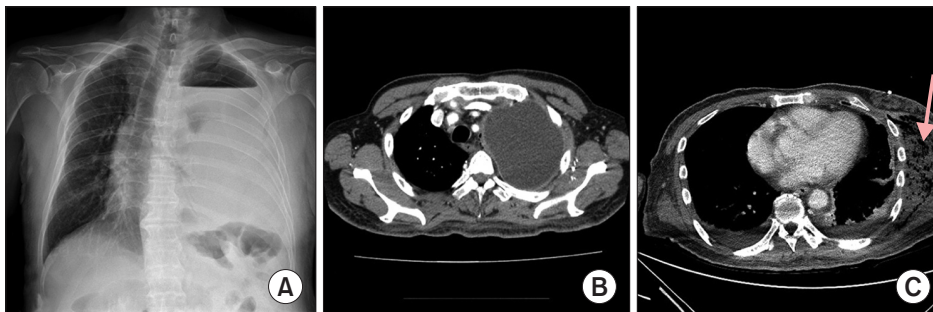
(A) Initial chest X-ray. (B) Computed tomography (CT) revealing left thoracic empyema. (C) Preoperative chest CT; the arrow indicates necrotized muscle.
